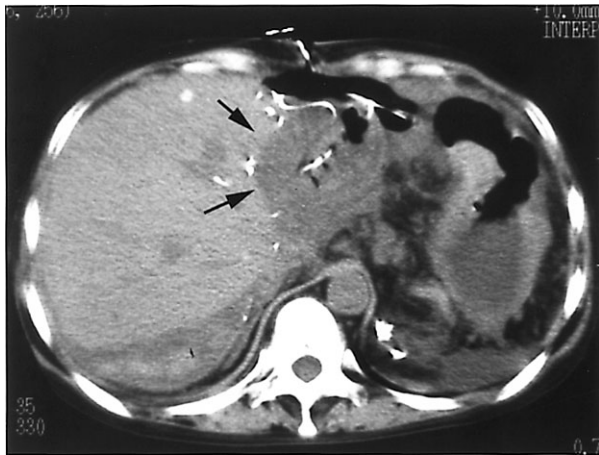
Computed tomogram shows fluid collection around the reconstructed jejunum (arrows).
